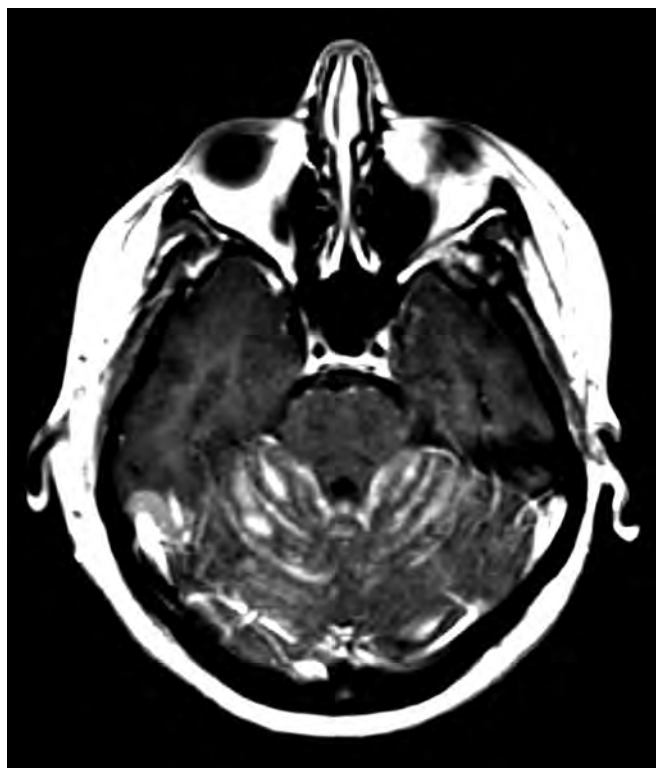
Leptomeningeal metastases from breast cancer. Axial gadolinium-enhanced brain magnetic resonance imaging reveals diffuse nodular enhancement in the preponine cistern as well as the cerebellar folia. This image is diagnostic.
